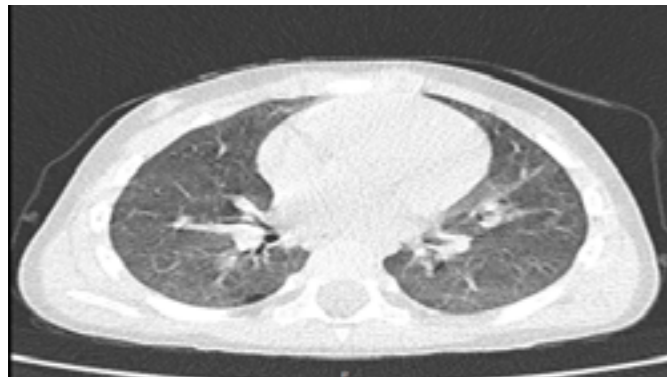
Chest CT scan. Multifocal, bilateral, and peripheral Ground glass (GGO), mainly in the lower lobes and less frequently in the middle lobe. Traction bronchiectasis is seen in the areas of ground glass. (Septal thickening, pleural thickening, subpleural involvement, pleural effusion, pericardial effusion, lymphadenopathy, cavitation, CT halo sign, and pneumothorax were not observed in our patient).
